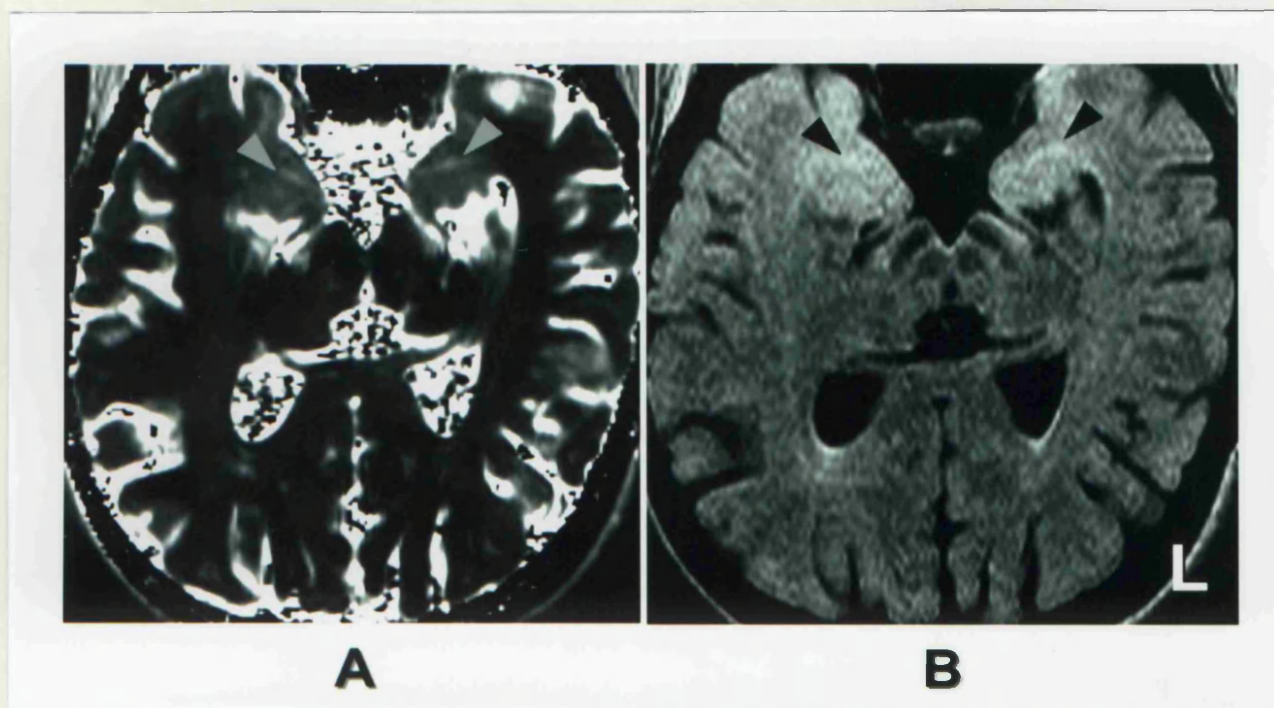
Isolated bilateral AT2 abnormalities. Patient was a 26 year old woman who had a FC at the age of two years and subsequently developed intractable TLE from the age of five years. Auras were characterized by panic, an epigastric rising sensation and déjà vu. Interictal EEGs showed bilateral fronto-temporal epileptiform discharges. A standard MRI was normal and hippocampal quantitation was normal: HCT2 right = 108 msec, HCT2 = 108 msec (NI: ≤ 108 msec), HCVR = 0.98 (NI: ≥ 0.87), HCV right = 5530 mm³, HCV left = 5402 mm³, (NI: ≥ 4348 mm³). The AT2 map (A) showed bilateral increased AT2 values of 109 msec on the right, and 108 msec on the left (NI: ≤ 104 msec). The T2 values of the brighter regions in the amygdalae (gray arrows), measured with a small circle, were 119 msec on the right and 121 msec on the left. The FLAIR image (B) showed bilateral increased signals in the amygdalae with a streak-like and elongated shape (black arrows), in the same position as those seen on the AT2 map, confirming the tissue origin of the increased signal. [Hospital number: QSC28724].
